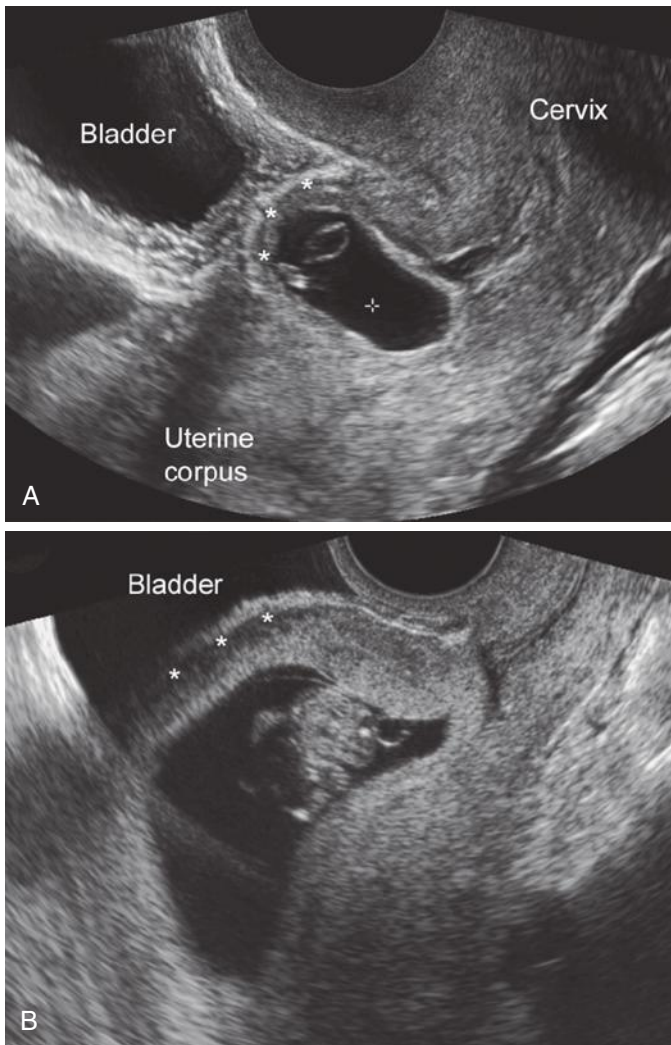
Cesarean scar pregnancy with attenuation of retroplacental myometrium. A, In this transvaginal image of a 6-week gestation, the gestational sac is implanted low and anteriorly in the uterus (in the region of the hysterotomy scar) and appears to bulge outwardly; there is no visible myometrial layer (*asterisks*) between the gestational sac and maternal bladder. B, This transvaginal sonogram at 11 weeks shows thinning of the myometrial layer (*asterisks*) between the gestational sac and the bladder.
